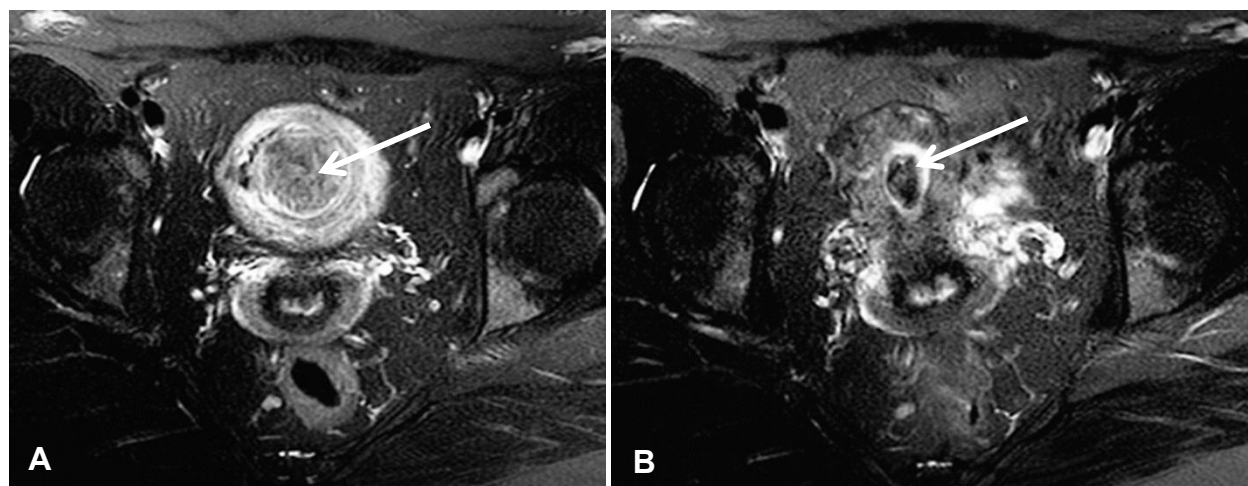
42-year-old female with a large uterine fibroid. (A) Axial T2-weighted fat-suppressed image of fibroid pre-embolization; fibroid measures 35.2mm. (B) Axial T2-weighted fat-suppressed image after embolization; fibroid measures 13.4 mm.
